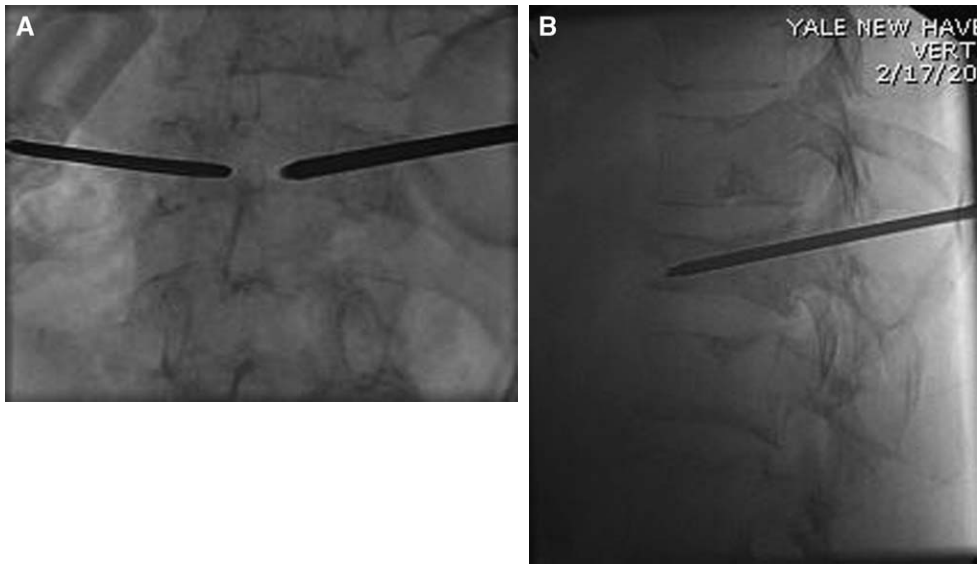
Frontal (*A*) and lateral (*B*) radiographs demonstrate placement of cannulas through pedicles into the anterior third of the vertebral body.
